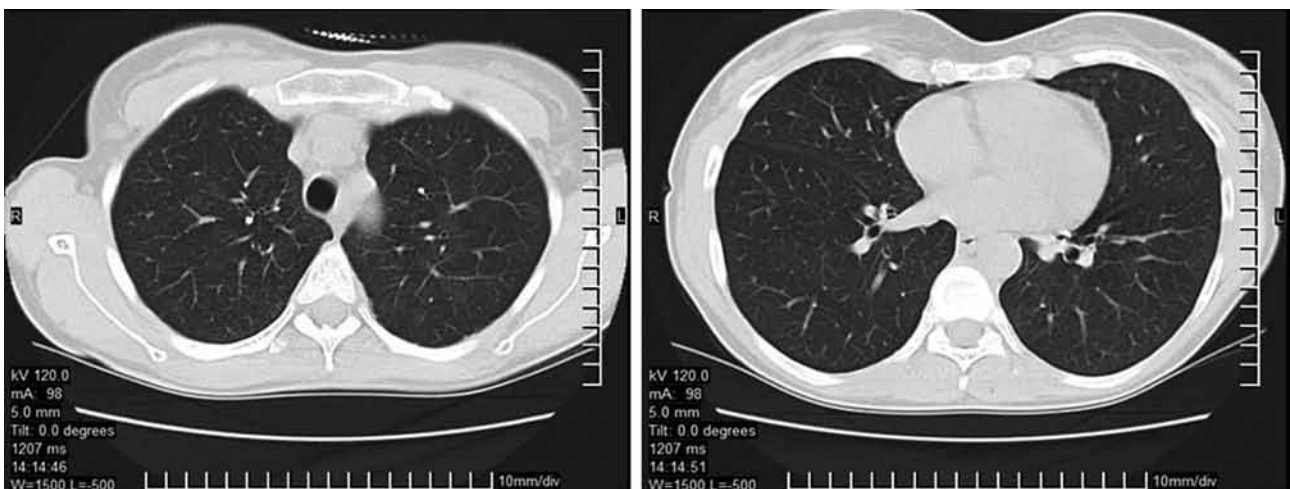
HRCT, 15 days after work discontinuation. Almost complete resolution of ground-glass opacities is noted.
